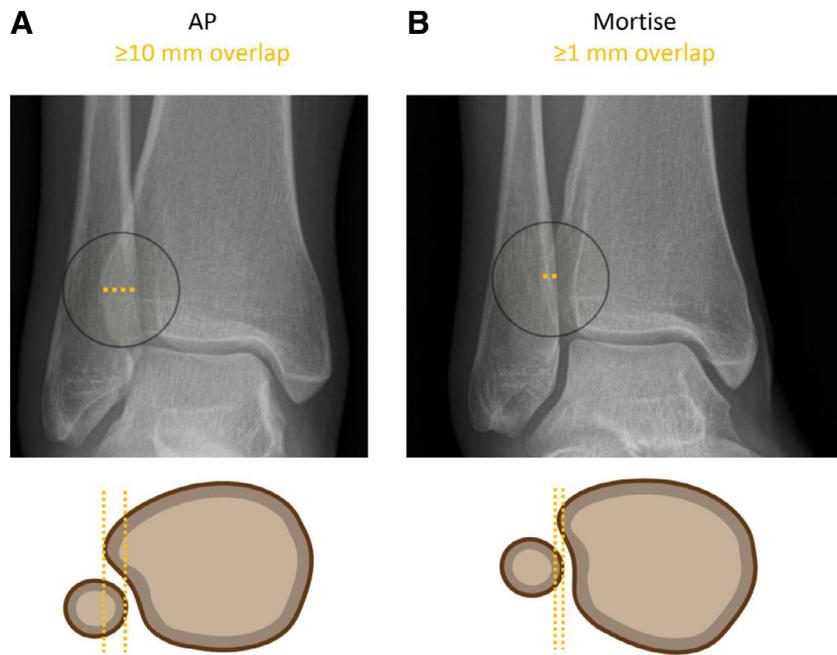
Radiographic measurement tibiofibular overlap on AP (A) views and mortise views (B) with the figures below the radiographs demonstrating how the medial border of the fibula and the anterior tibial tubercle form the respective shadows that define the tibiofibular overlap.
